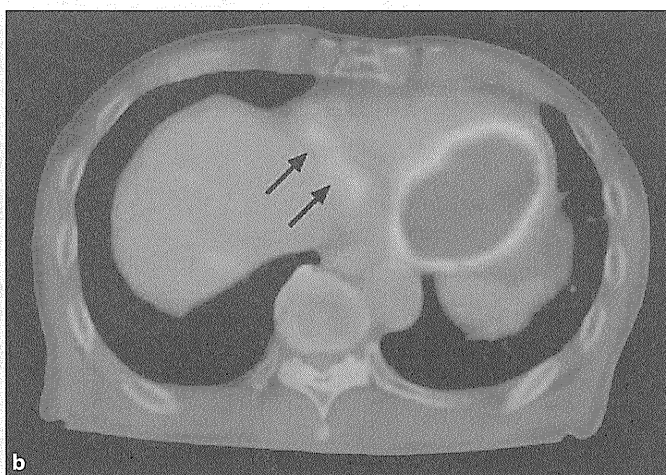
Abdominal computed tomography showing the increased wall thickness of the abdominal aorta (arrows).
